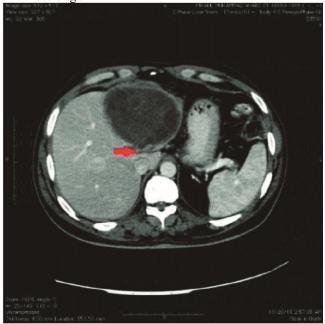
CT scan showing a large hydatid cyst and a fistula commutating between hydatid cyst and the biliary system.
